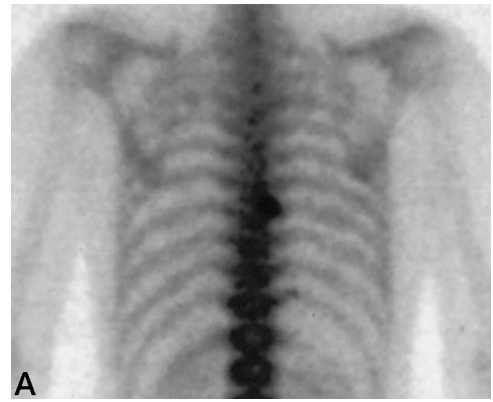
25-year-old man with back pain for 18 months, which was dramatically relieved by aspirin. Radiographic findings were normal.
